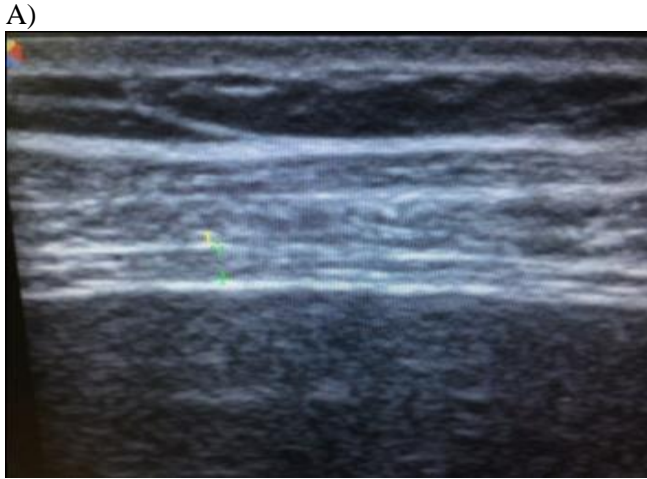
Diaphragmatic ultrasonography of a male patient with moderate COPD
